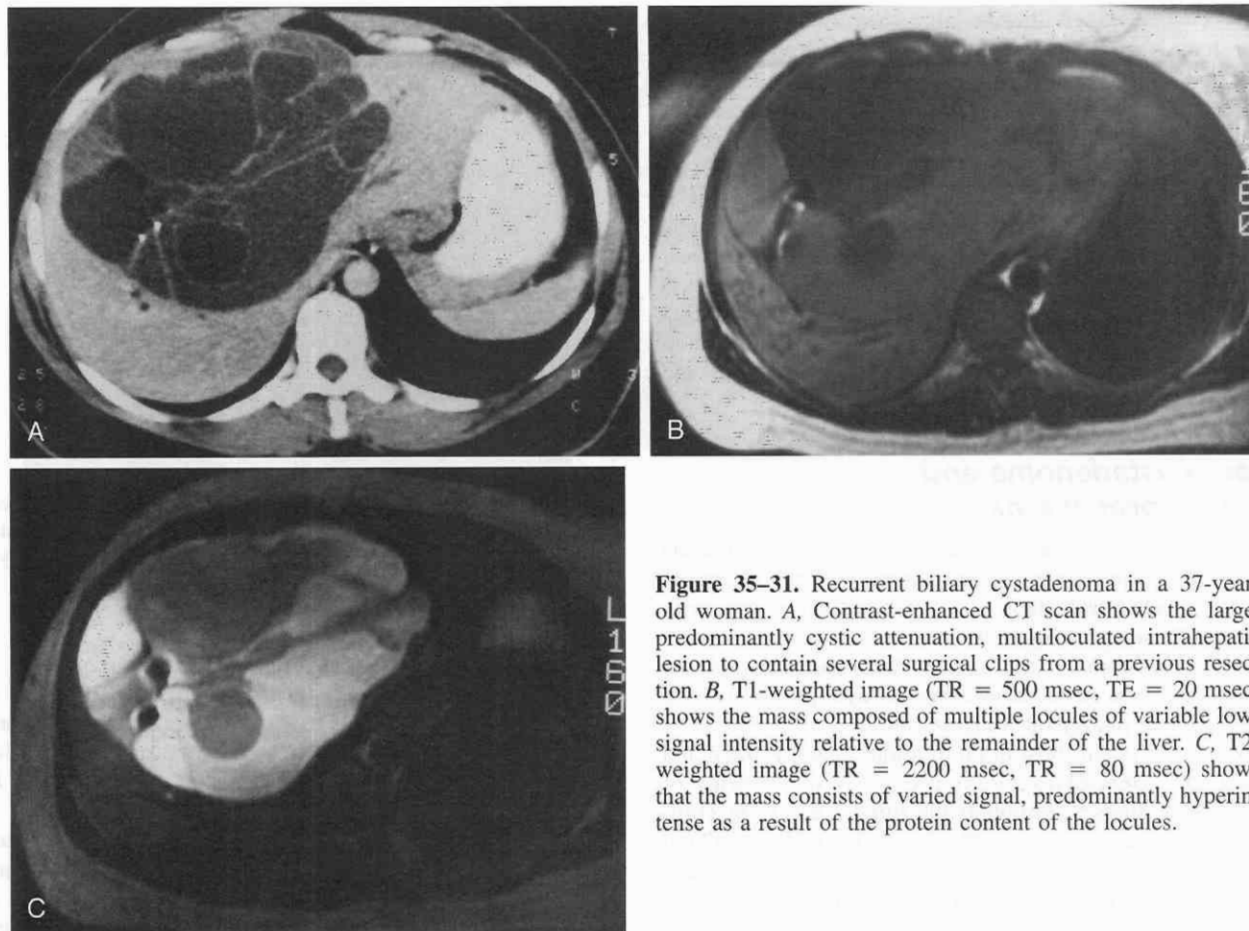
Recurrent biliary cystadenoma in a 37-year-old woman. *A*, Contrast-enhanced CT scan shows the large, predominantly cystic attenuation, multiloculated intrahepatic lesion to contain several surgical clips from a previous resection. *B*, T1-weighted image (TR = 500 msec, TE = 20 msec) shows the mass composed of multiple locules of variable low-signal intensity relative to the remainder of the liver. *C*, T2-weighted image (TR = 2200 msec, TE = 80 msec) shows that the mass consists of varied signal, predominantly hyperintense as a result of the protein content of the locules.
